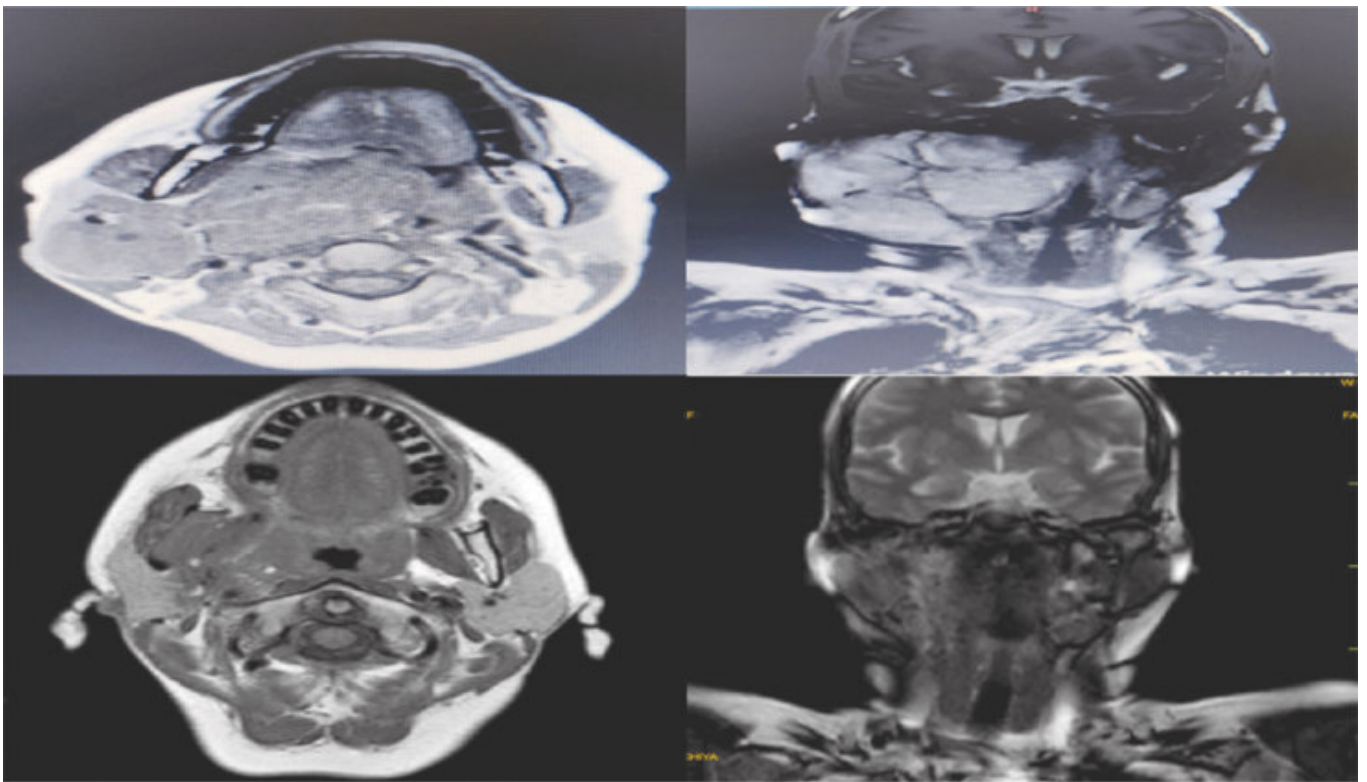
MRI with contrast (T2W) axial and coronal sections A, B- Preoperative C, D- Postoperative
